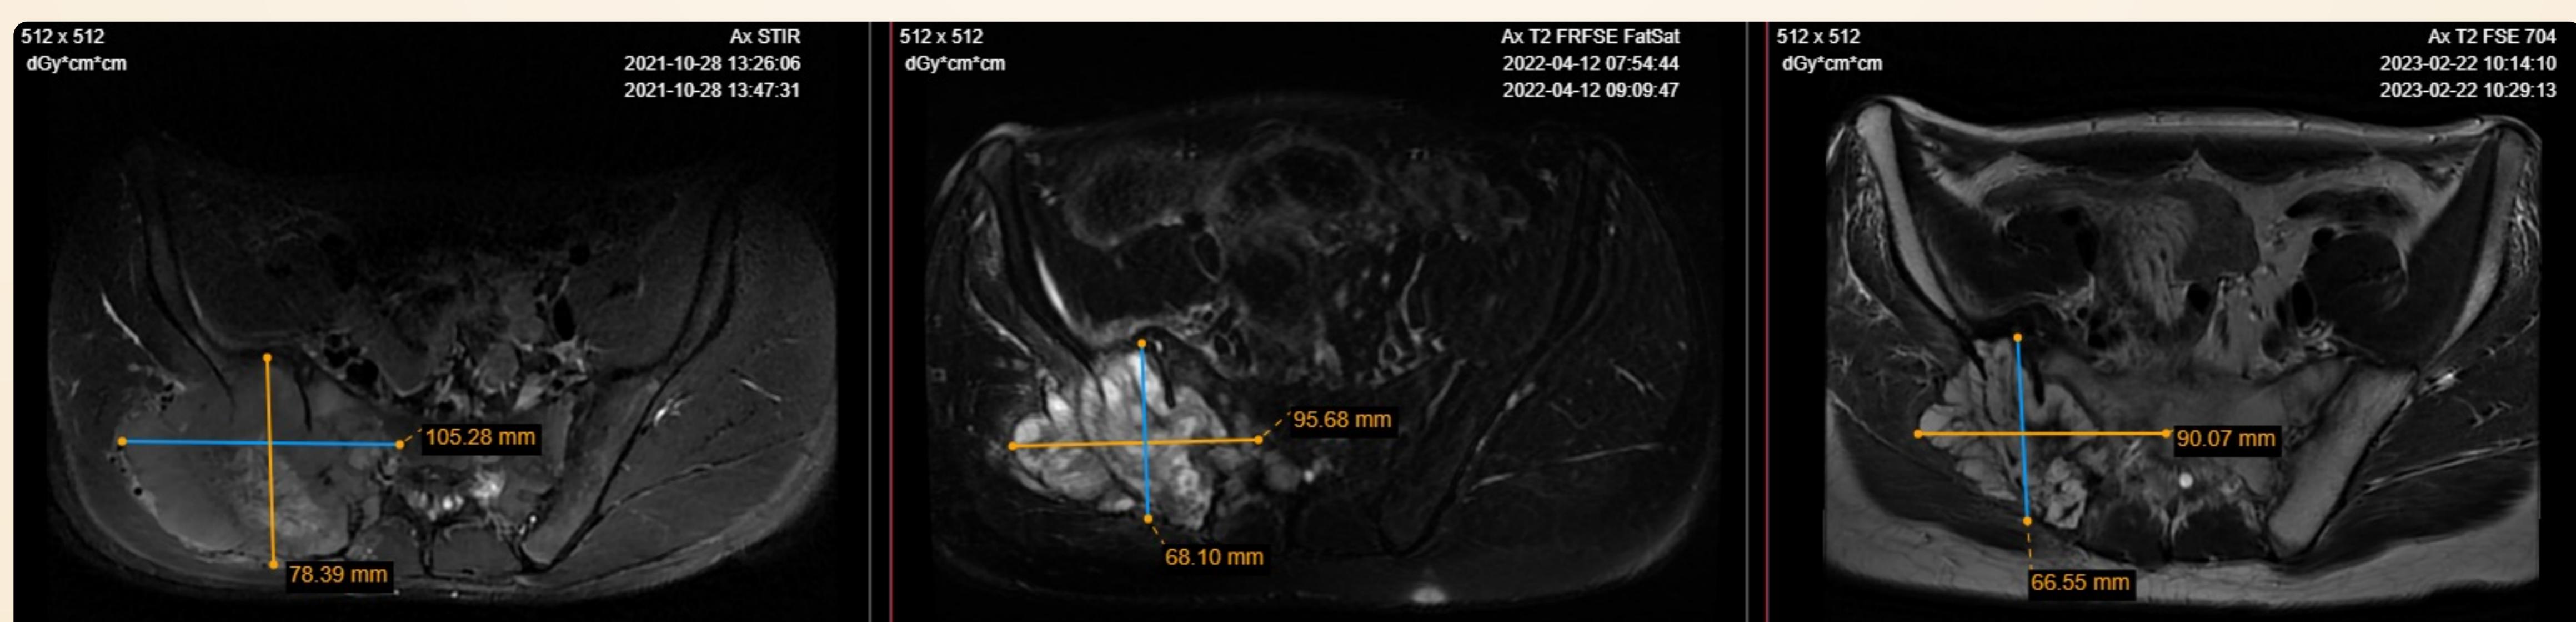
From left to right - initial MRI findings of the primary Ewing sarcoma tumour, control MRI after neoadjuvant treatment, latest control MRI after radiotherapy and 12 irinotecan/temozolomide cycles.
